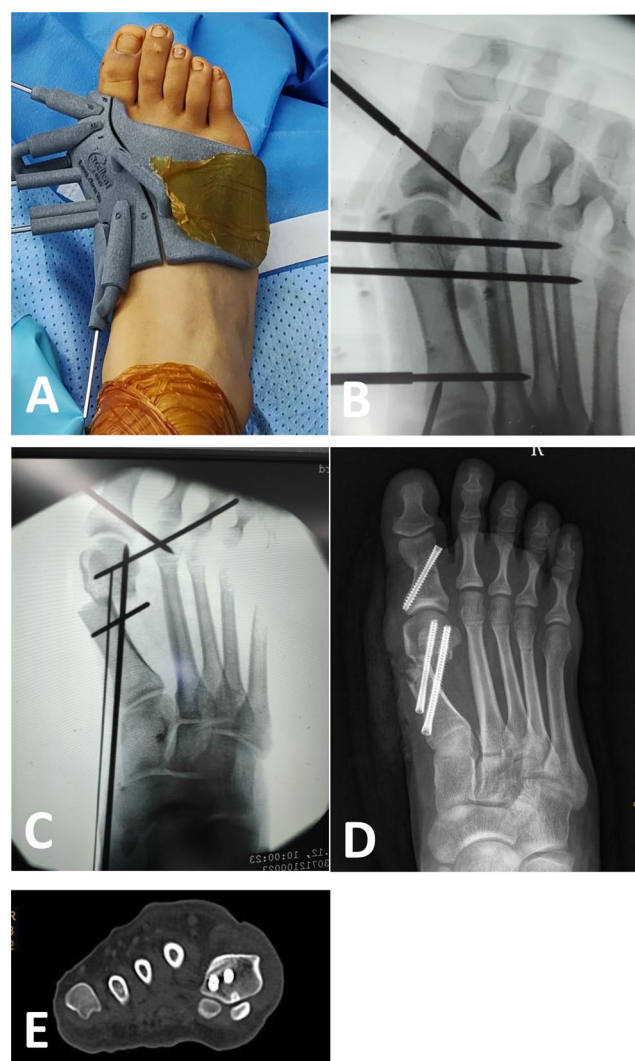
Surgical steps. A The guide was fixed on the foot. B A Kirschner wire was inserted through the guide, and then osteotomy was performed, followed by hallux valgus deformity correction, which was confirmed by C-arm fluoroscopy. C After correction, the Kirschner wire was inserted to assist final screw insertion. D and E Postoperative radiographic and CT scans of the foot showing that the HVA, IMA, and M1PA had returned to normal
